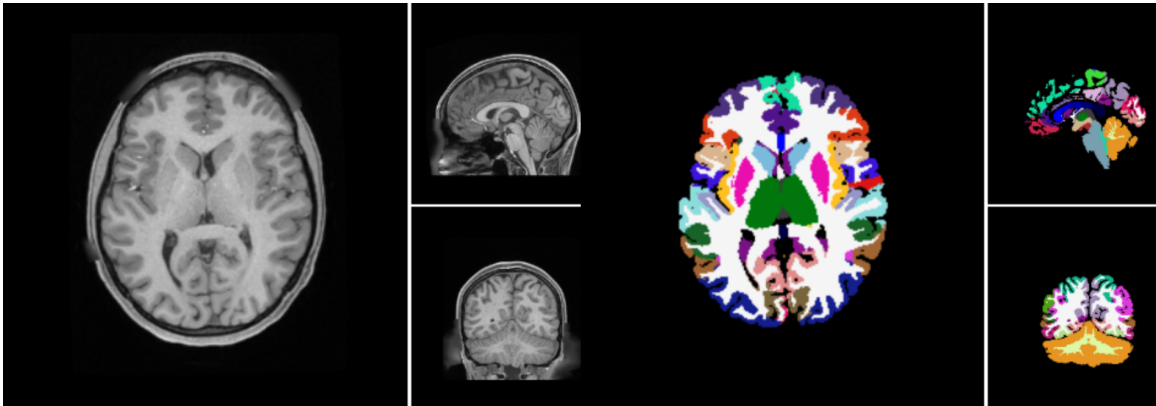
MRI before and after segmentation
